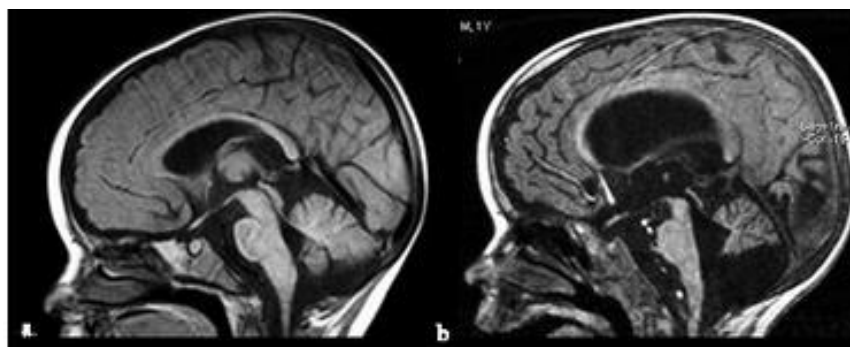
Sagittal T1-weighted images performed at six-months age (a) and sixteen-months age (b) Supratentorial and infratentorial atrophy is well depicted*
